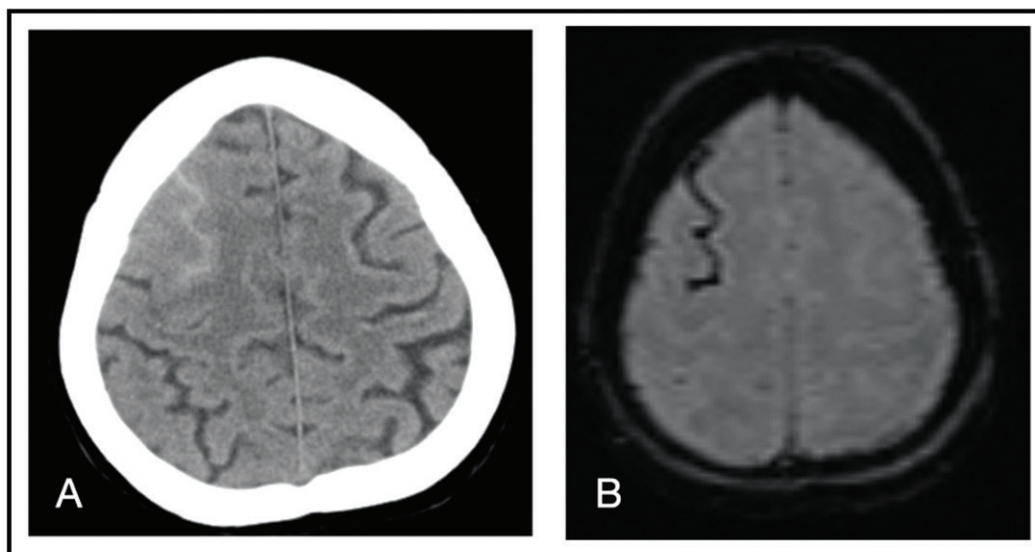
A) CT Brain showing right frontal subarachnoid hemorrhage. B) Axial SWI sequence showing blooming in the same region
